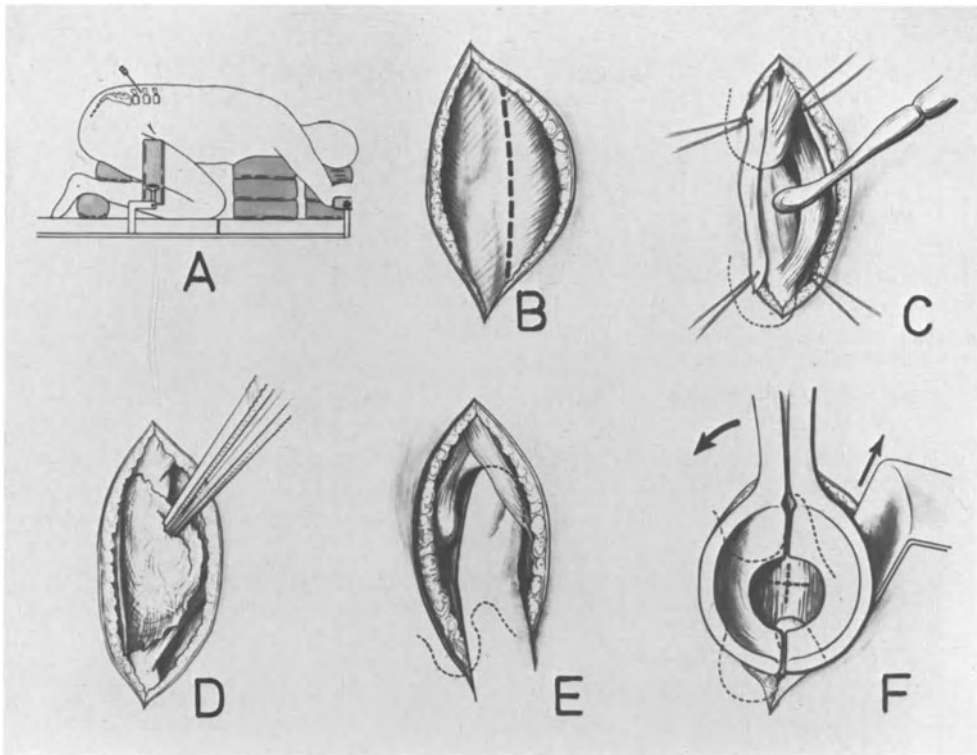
A: Location and marking of the segment to be operated on by means of a puncture cannula and X-ray control
